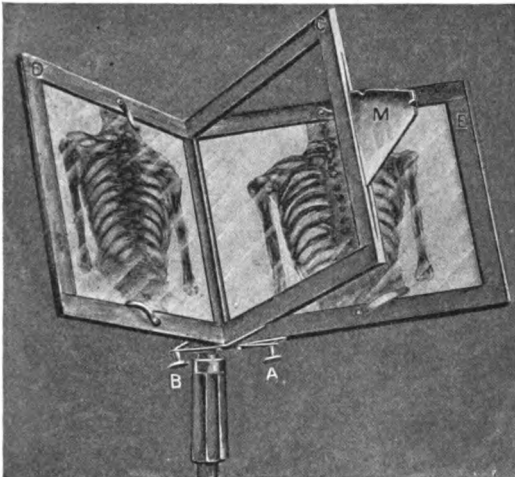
Pigeon's reflecting stereoscope for examining radiographs.
